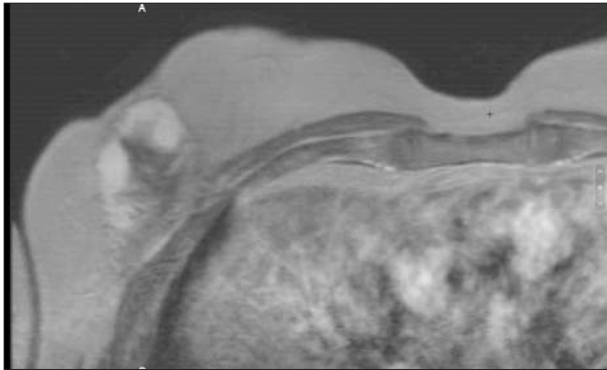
Transverse MRI 1
